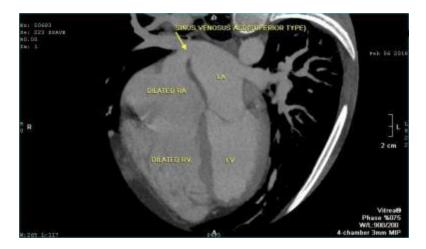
multi-slice CT, sinus venosus ASD, dilated RA, RV.
